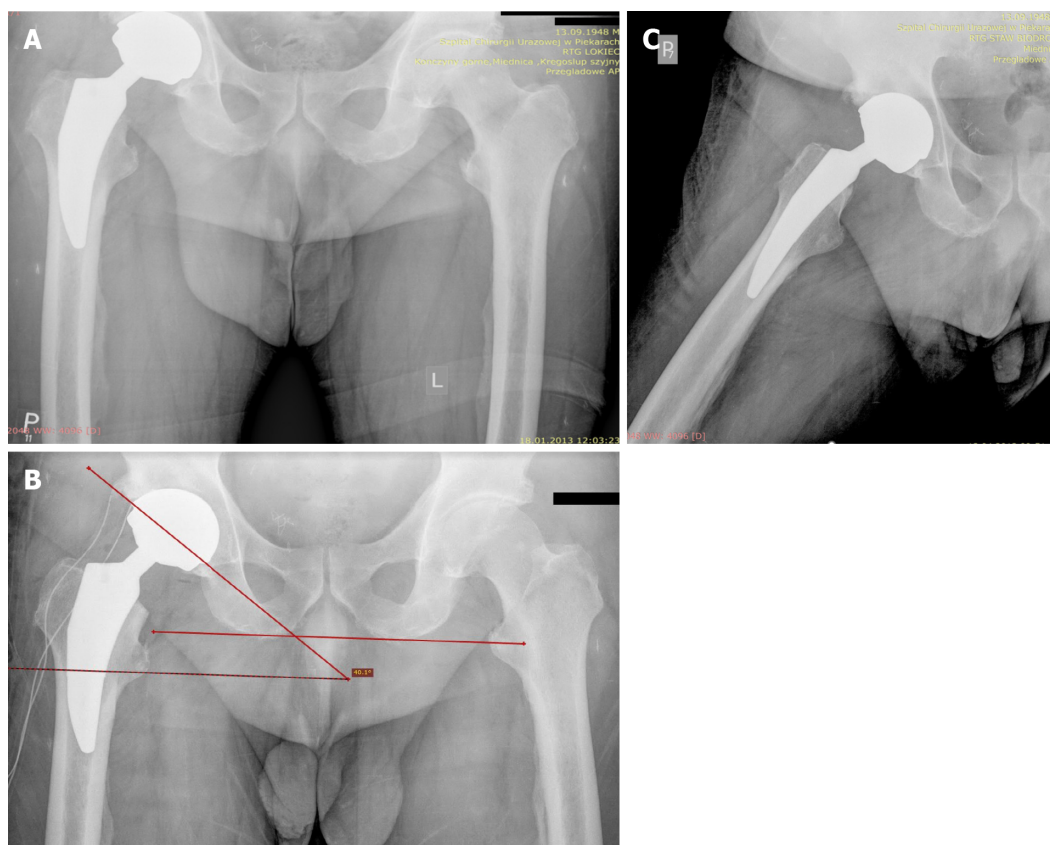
X-ray images after total right hip replacement surgery. A: At 1 yr postoperative; B: At 4 months postoperative, the inclination angle before revision arthroplasty was 40.1°; C: In lateral view at 4 months postoperative.
